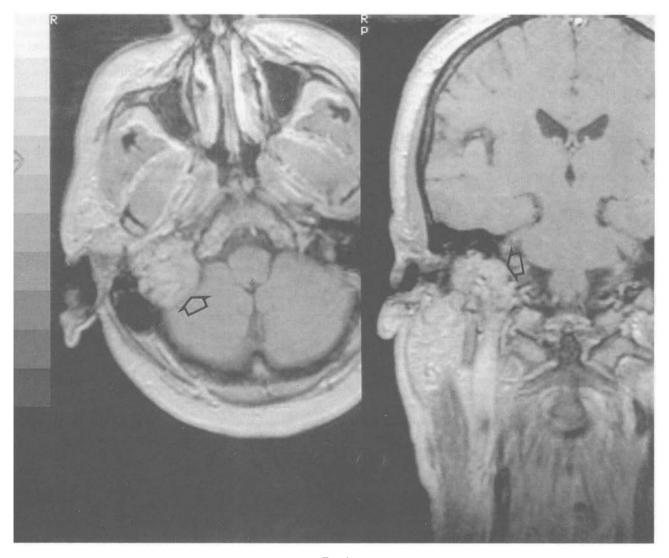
Axial and sagittal T1 weighted MRI scans of tumour (arrowed), after intravenous gadolinium-DTPA injection.
